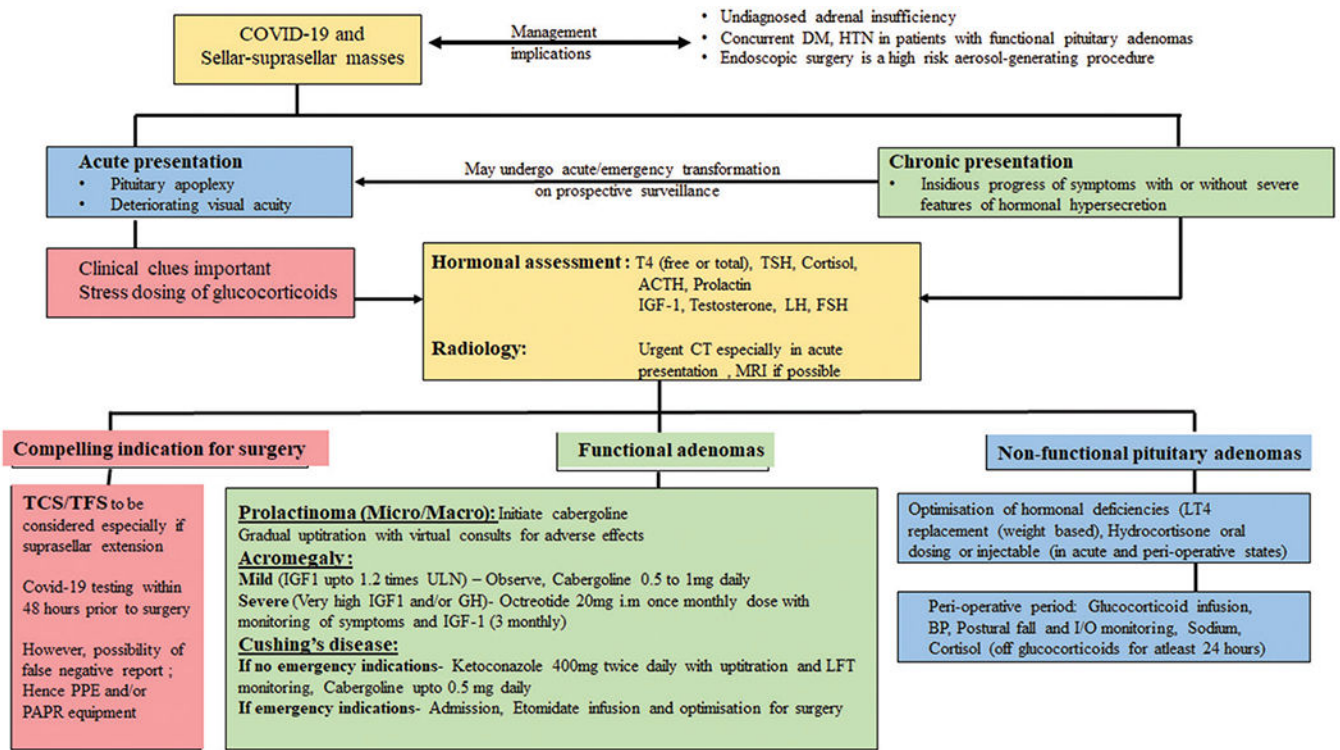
Proposed algorithm for remodelling of endocrinological management of pituitary adenomas during the COVID crisis (ACTH- Adrenocorticotrophic hormone; BP- Blood pressure; CT- Computerised tomography; DM- Diabetes mellitus; FSH- Follicle stimulating hormone; HTN- Hypertension; I/O- Input/output IGF-1- Insulin like growth factor-1; LT4- Levothyroxine; LFT- Liver function test; LH- Luteinising hormone; MRI- Magnetic resonance imaging; PAPR- Powered air-purifying respirator; PPE- Personal protective equipment; T4- Tetraiodothyronine; TSH- Thyroid stimulating hormone; TCS- Transcranial surgery; TFS- Trans-frontal surgery; ULN- Upper limit of normal;)
